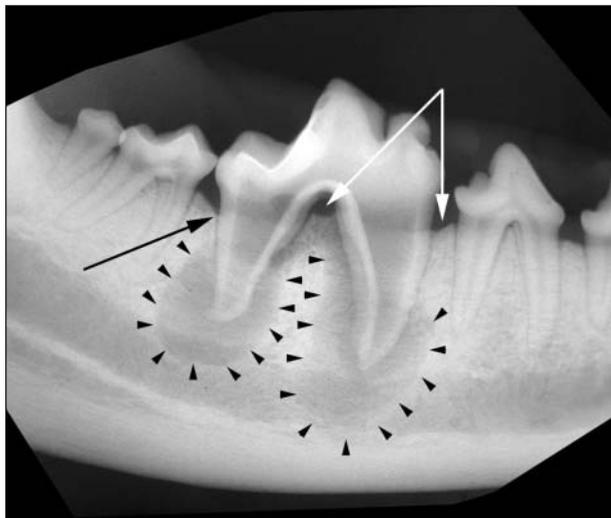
Same radiographic view as in Figure 2A. Notice the large radiolucencies surrounding the apices of both roots of the right mandibular first molar (black arrowheads). In addition, there is moderate horizontal bone loss at the mesial root and an absence of bone in the furcation region (white arrows) and mild vertical bone loss at the distal aspect of the distal root (black arrow).
